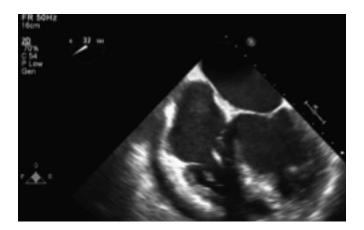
Preoperative transesophageal echo demonstrating enlarged but intact intraventricular septum. Preoperative 4-chamber view of transesophageal echo demonstrates intact intraventricular septum without obvious vegetations. Pericardial effusion is noted.
